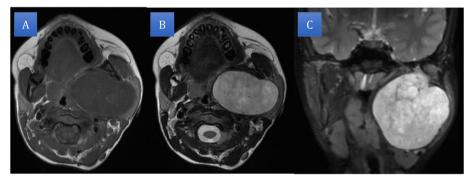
Contrast-enhanced MRI showing the tumor to be well defined, T1 isointense A and T2 hyperintense B, C
